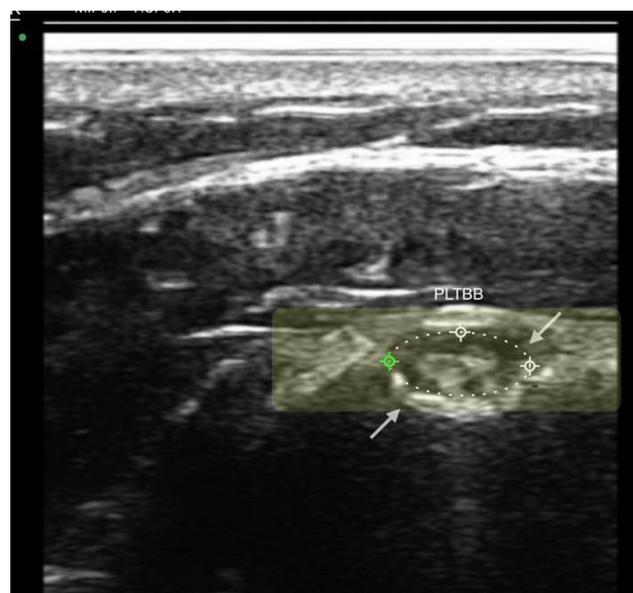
In the short axis of the musculoskeletal ultrasonography technique, the tendon of the long portion of the biceps on the right side was evidenced with the presence of an anechoic region suggestive of fluid in the synovial sheath and significant peritendinous effusion.
